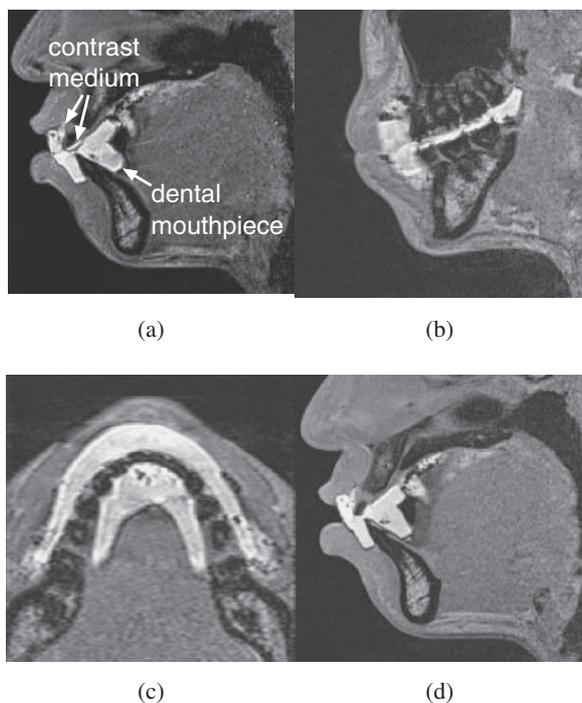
Anterior-to-posterior MR images on the (a) mid-sagittal plane, (b) sagittal plane passing through the left posterior teeth, and (c) transverse plane passing through the lower teeth, and (d) posterior-to-anterior MR image on the mid-sagittal plane.
